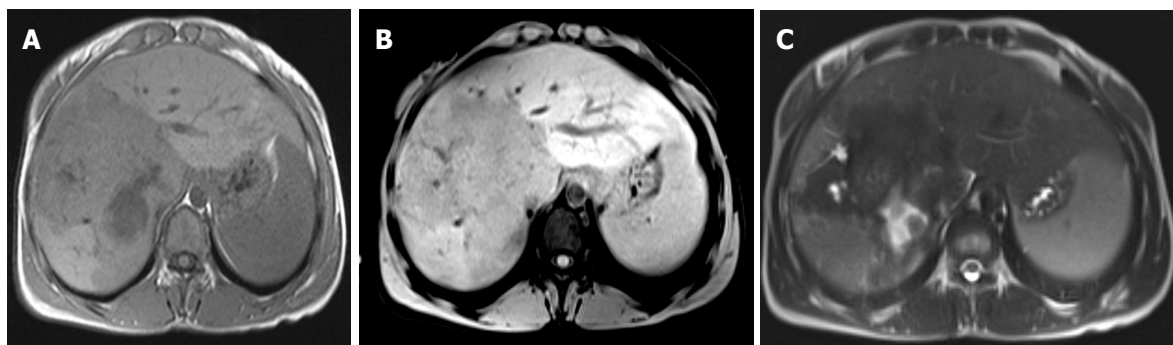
Alveolar echinococcosis in a 39-year-old man. Axial unenhanced T1-weighted image show an infiltrating hypointense mass in the right lobe of the liver (A). Axial magnetic resonance imaging obtained after the administration of intravenous contrast medium show no contrast enhancement within the mass (B). Axial T2-weighted image show an infiltrating hyperintense mass in the right lobe of the liver (C).
